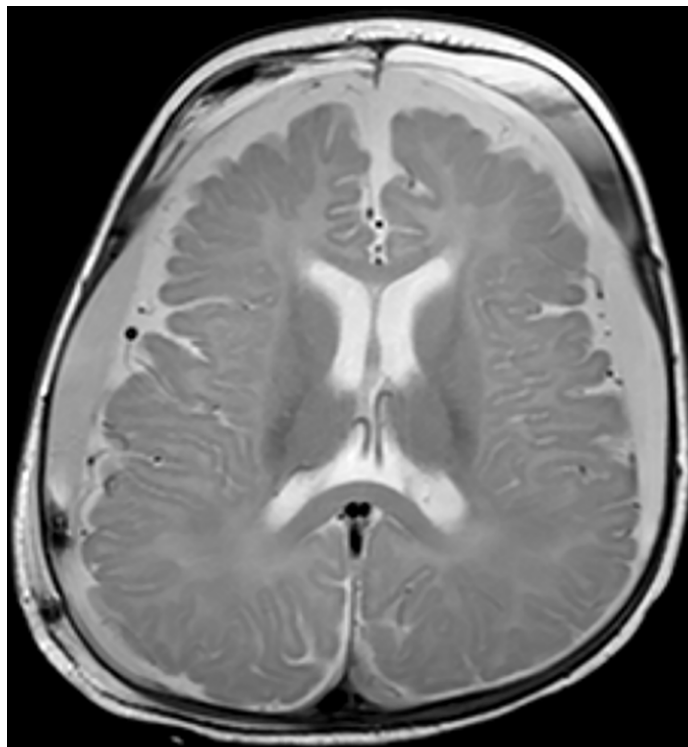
Axial T2-weighted MR image of the brain in an infant who experienced AHT shows bilateral holo-hemispheric mixed-signal-intensity subdural hematomas with a chronic component. Membranes or loculations visible within a subdural collection are one of the few findings that allow accurate radiologic dating (>2 weeks). The term *acute-on-chronic* is commonly used in both CT and MRI reports but should usually be avoided due to difficulties presented in the medicolegal setting. Descriptive language describing the anatomic location and attenuation or signal intensity is usually preferred.
